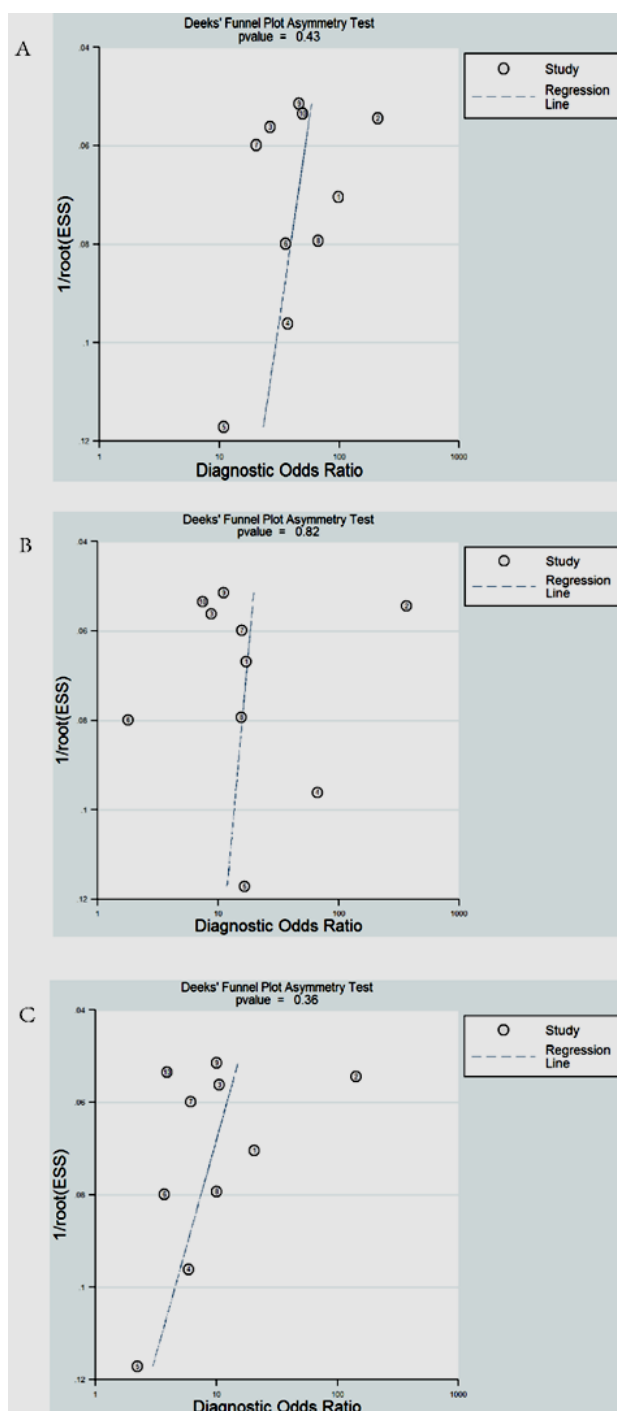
Publication bias of BSGI (A), ultrasound (B), and mammography (C) using Deek's funnel plot.
